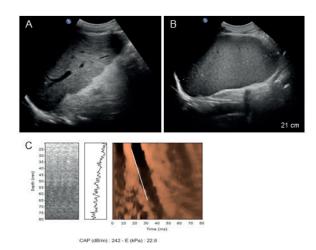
(A) Liver and (B) spleen ultrasonography; (C) controlled attenuation parameter (CAP) and elasticity (E) by transient elastography.
